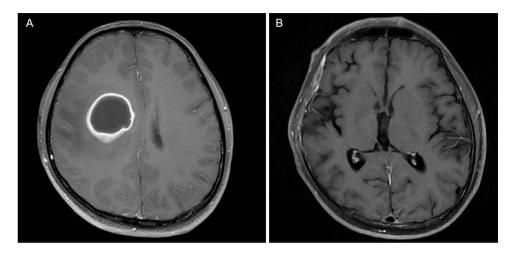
Enhanced cranial magnetic resonance imaging in patients with intracranial infections on T₁-weighted images. (A) On October 23, 2022, rounded nodular abnormaldensity foci about 2.9×3.6 cm in size could be seen in the right frontoparietal lobe. (B) After 7 weeks of treatment, no significant foci of enhancement could be observed.
